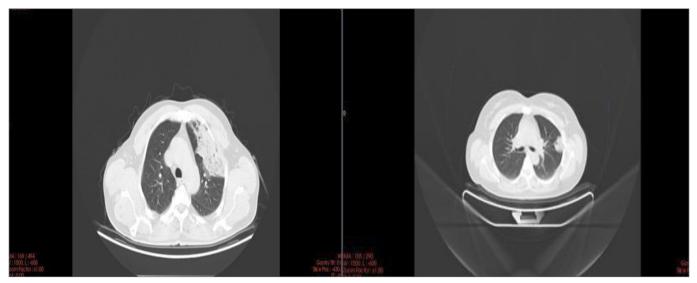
Pneumonia-like area of infiltration or consolidation involving a region of the lung. 61-year-old male patient was diagnosed with invasive adenocarcinoma by transthoracic biopsy in the consolidated lesion in the upper lobe of the left lung, and left upper lobectomy was performed. Image-2: 52-year-old male patient underwent lobectomy for the consolidated lesion on thoracic computed tomography
